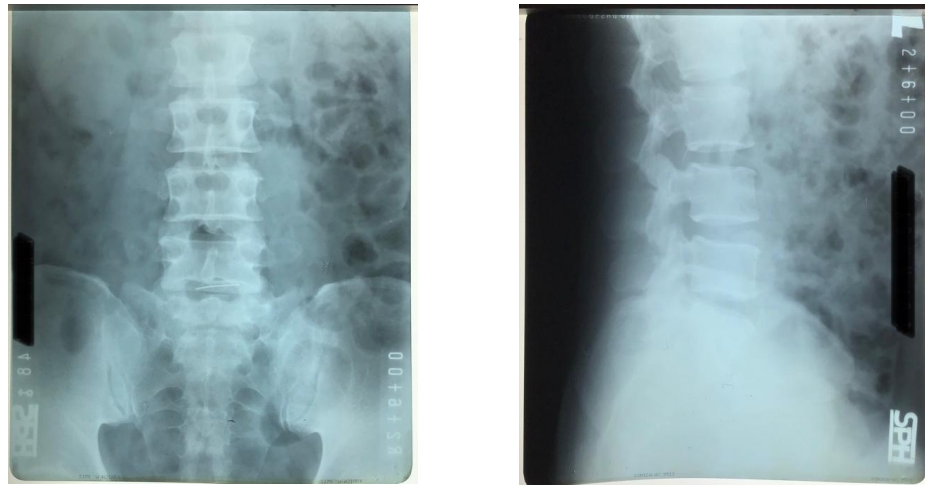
Lumbar Xray AP and Lateral View before Operation
